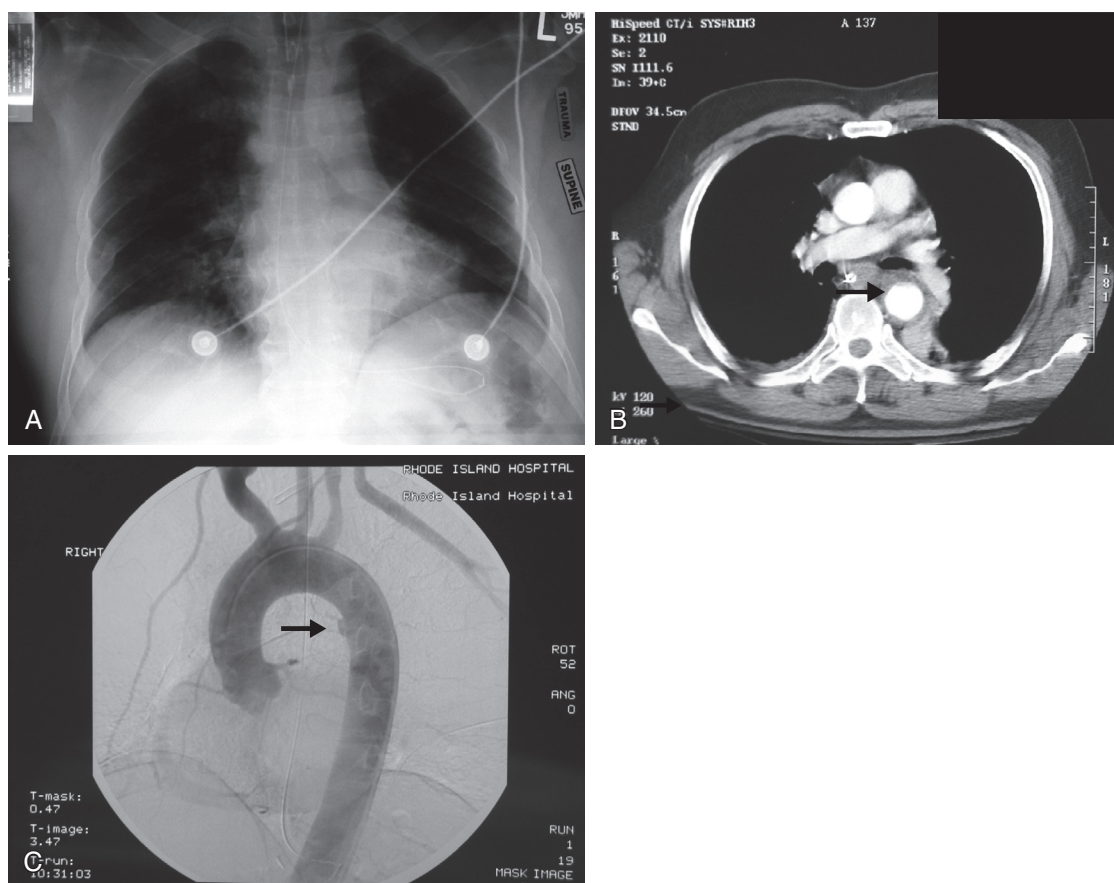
■ Images from patient with descending thoracic aortic injury. A, Anteroposterior chest radiograph. Note widened mediastinum and widened left paratracheal stripe, indistinct aortic knob, and slight depression of left mainstem bronchus. B, Helical computed tomography (CT) scan of chest. Note periaortic hematoma (arrow). C, Digital subtraction arteriogram of aortic arch. Note pseudoaneurysm in the common location, distal to left subclavian artery (arrow).
